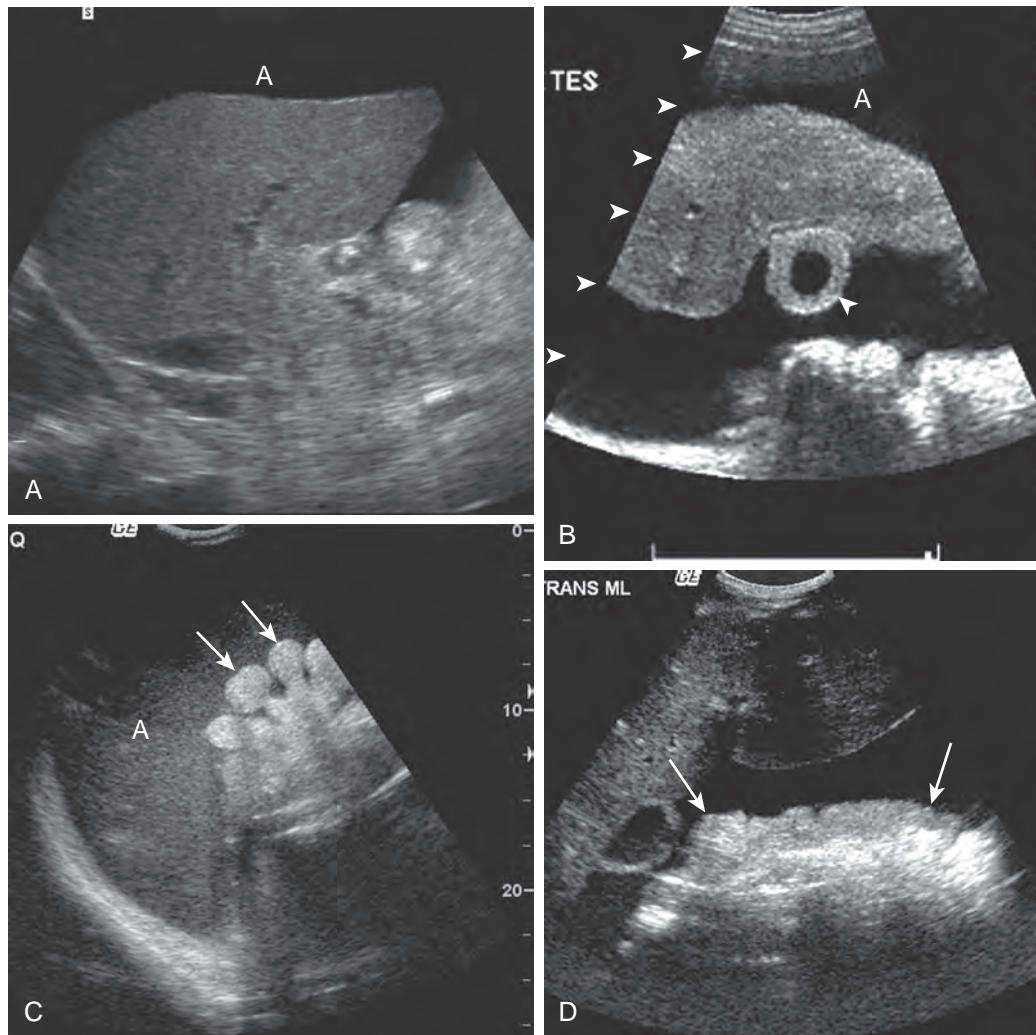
Ascites: sonographic findings. A. The sonogram of transudative ascites (A) in a patient with cirrhosis of the liver shows anechoic fluid and an echogenic liver. B. Mural thickening of the gallbladder (arrowhead) is seen in this patient with cirrhosis and ascites (A). Gallbladder wall thickening in the presence of ascites suggests benign disease. Normal mural thickness in the presence of ascites suggests malignant disease. C. The sonogram shows malignant ascites in a patient with carcinomatosis due to gastric cancer. Notice the echogenic fluid (A) and bowel loops (arrows) that are tethered posteriorly. Normally, these loops should be freely flowing. D. Peritoneal implants (arrows) are present in this patient with carcinomatosis.
